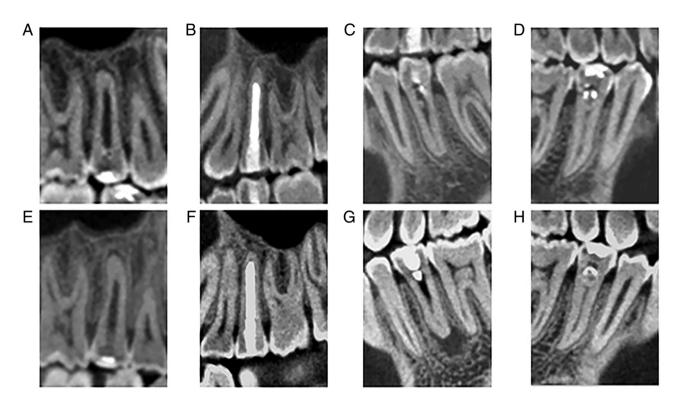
Follow-up CBCT after REPs. 5-year follow-up CBCT after REPs of teeth (A) #15, (B) #25, (C) #35 and (D) #45. 7-year follow-up radiograph after REPs of teeth (E) #15, (F) #25, (G) #35 and (H) #45. REPs, regenerative endodontic procedures; CBCT, cone-beam computed tomography.
